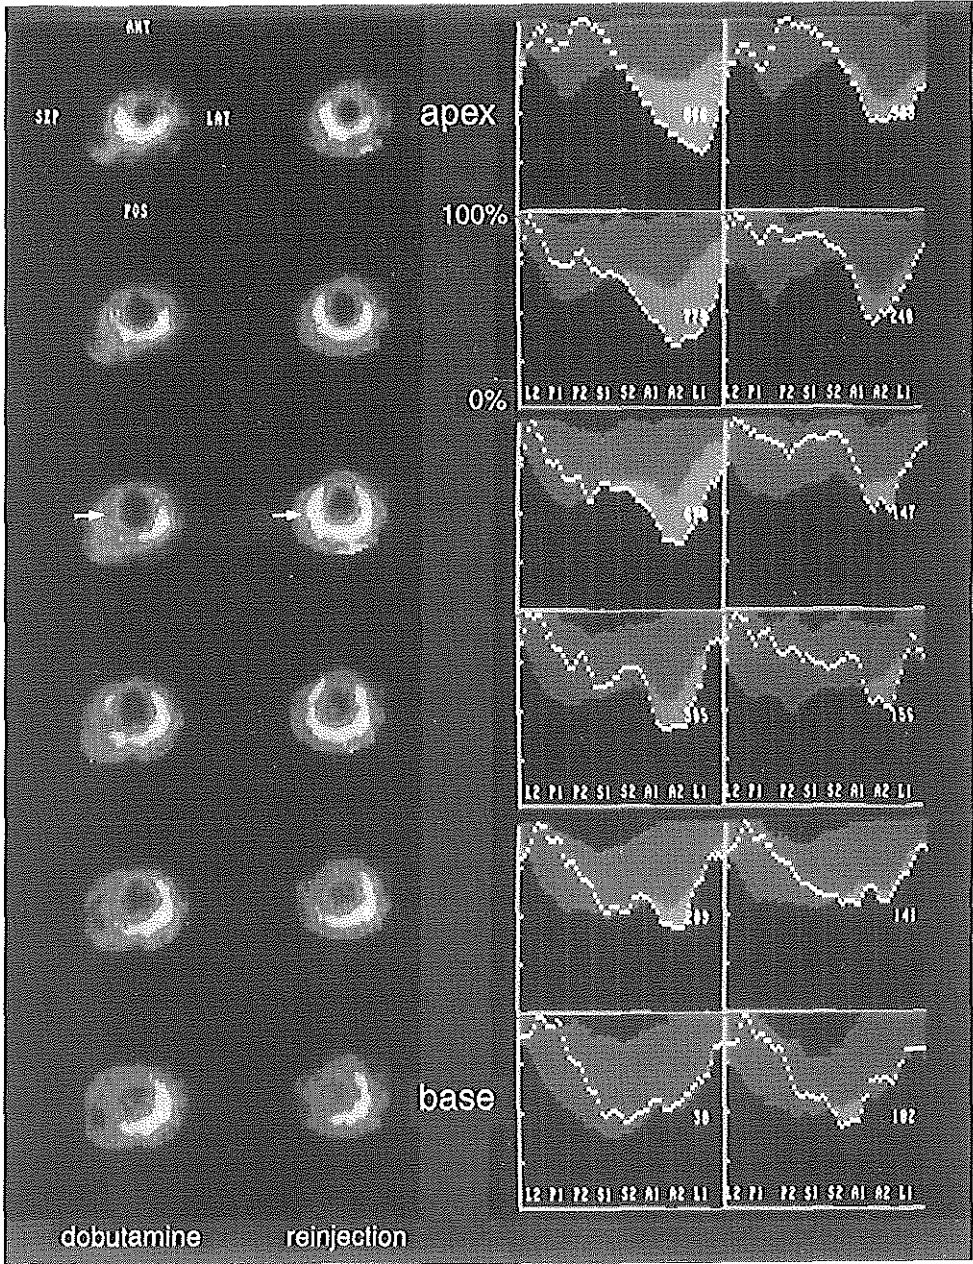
Preoperative dobutamine and reinjection 201 thallium SPECT images of the 6 short axis slices, provided with the corresponding circumferential profile. The images show a completely reversible defect in the septum (arrows).
